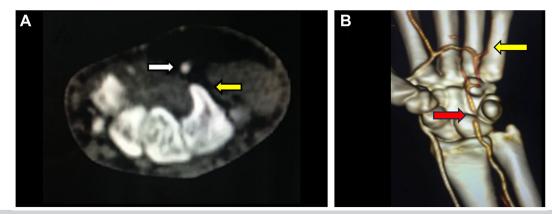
Computed tomography angiogram demonstrating hypothenar hammer syndrome (*HHS*). A, Crosssectional image at the level of the wrist showing the ulnar artery (*white arrow*) passing directly above the hook of the hamate (*yellow arrow*). B, Three-dimensional reconstructed image demonstrating occlusion of the distal ulnar artery at the level of the wrist (*red arrow*) and absent filling of the digital arteries (*yellow arrow*).
